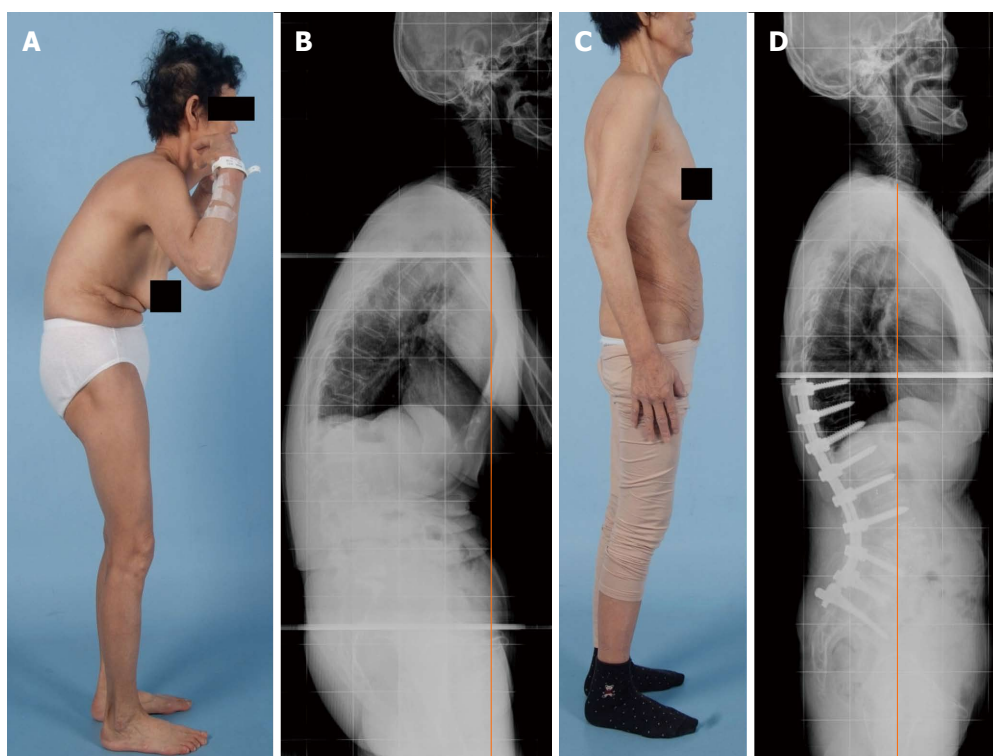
Pre- and post-operative clinical photographs (A)/radiographs (B) of a 65-year-old woman, revealing degenerative lumbar kyphosis with global sagittal imbalance. The patient presented with intolerable lower back pain and stooping symptoms. She underwent L4 pedicle subtraction osteotomy with anterior column support, and the plain film obtained at her most recent follow-up examination shows dramatic improvement in global sagittal alignment as well as the lumbar kyphosis (C and D).
